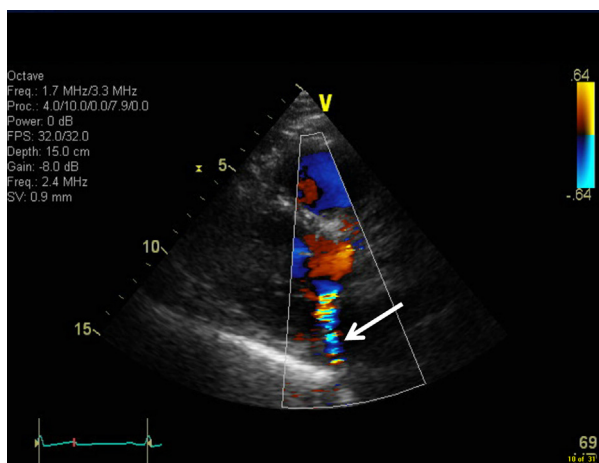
Transthoracic parasternal long axis view showing an eccentric jet of mitral regurgitation (arrow) on transmitral color-flow Doppler.
